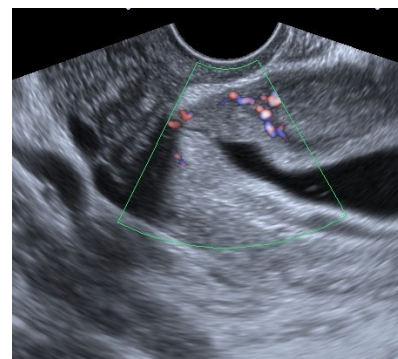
Type 1 CSP; Most of the gestational sac extends into the uterine cavity (white arrow). Mild blood circulation pattern that was not completely circular around the CSP was evaluated as "+" color Doppler blood supply
